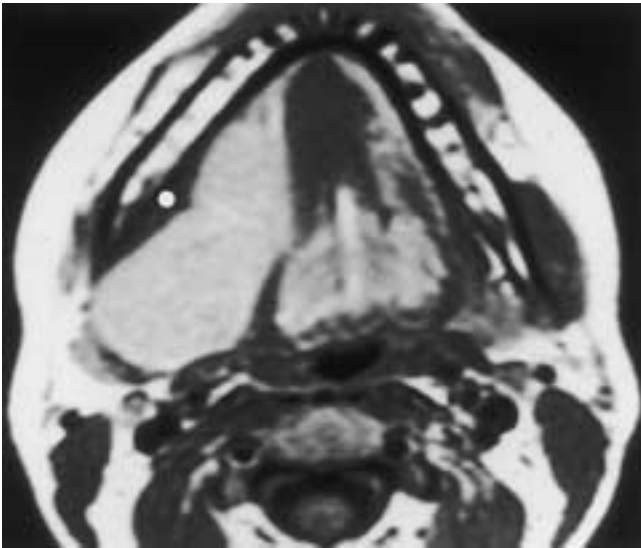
Dermoid cyst. Axial T1-weighted MR image reveals the lesion to be of high signal intensity but of slightly less intensity than that of the subcutaneous fat. The relationship of this lesion to the right mylohyoid muscle (*white dot*) is clearly established. The fatty lingual septum is displaced slightly to the left of midline. This lesion involves much of the right sublingual space, dissecting posteriorly to involve the deep aspect of the right submandibular space.
